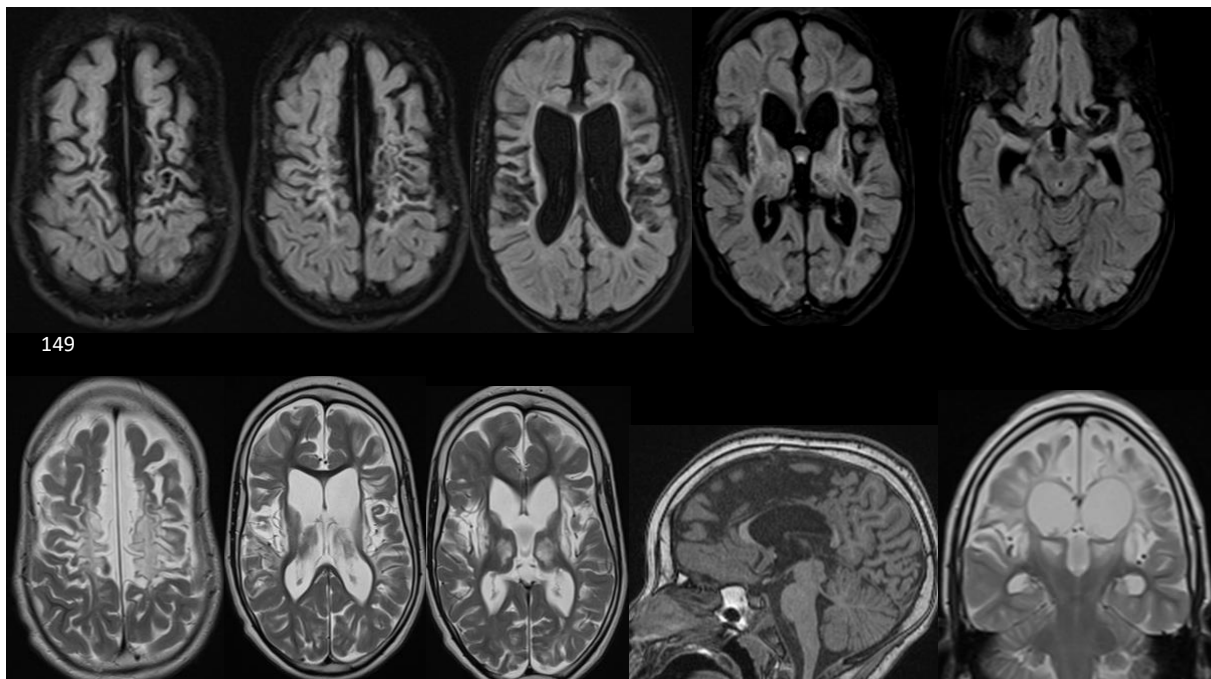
Collage of MRI images obtained for patient 149
